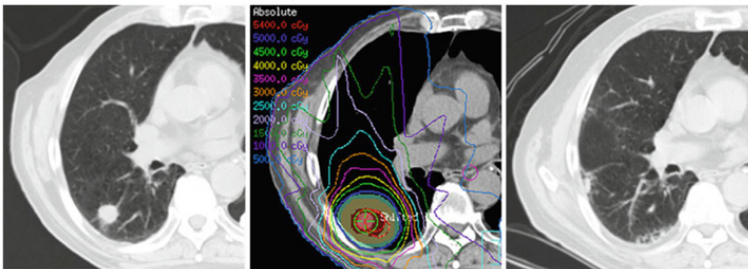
Example of SABR Treatment for Lung Cancer. The left panel demonstrates a non-small cell lung cancer in the right lung. The middle panel represents an example of a radiation treatment plan that focuses a high-dose of radiation on the cancer itself, sparing the normal tissues around it from excessive dose. The right panel demonstrates a follow-up CT scan approximately four-years after treatment showing a complete remission.
